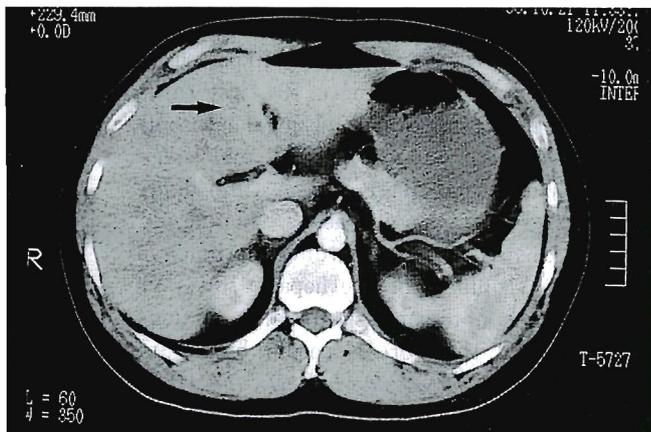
Dynamic CT in early phase (above) showing a slightly marginal enhancement effect of the low density region, while in the delayed phase (below), enhancement effect was unclear (Case 1).
